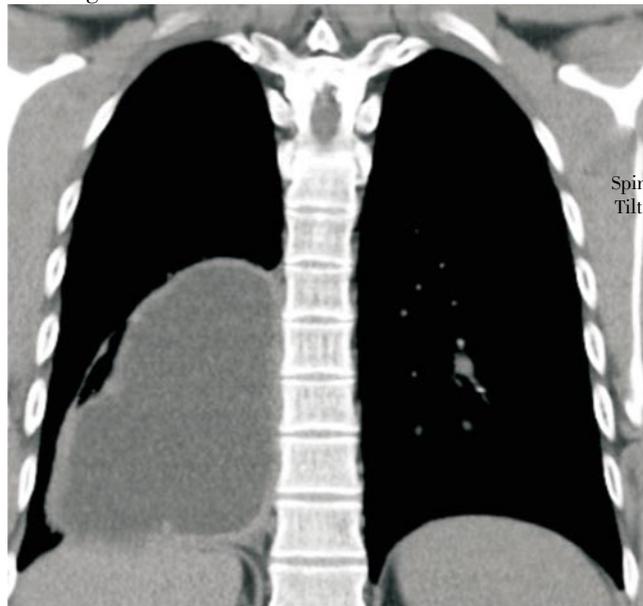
Chest CT showing cystic lesion in the right lung.
